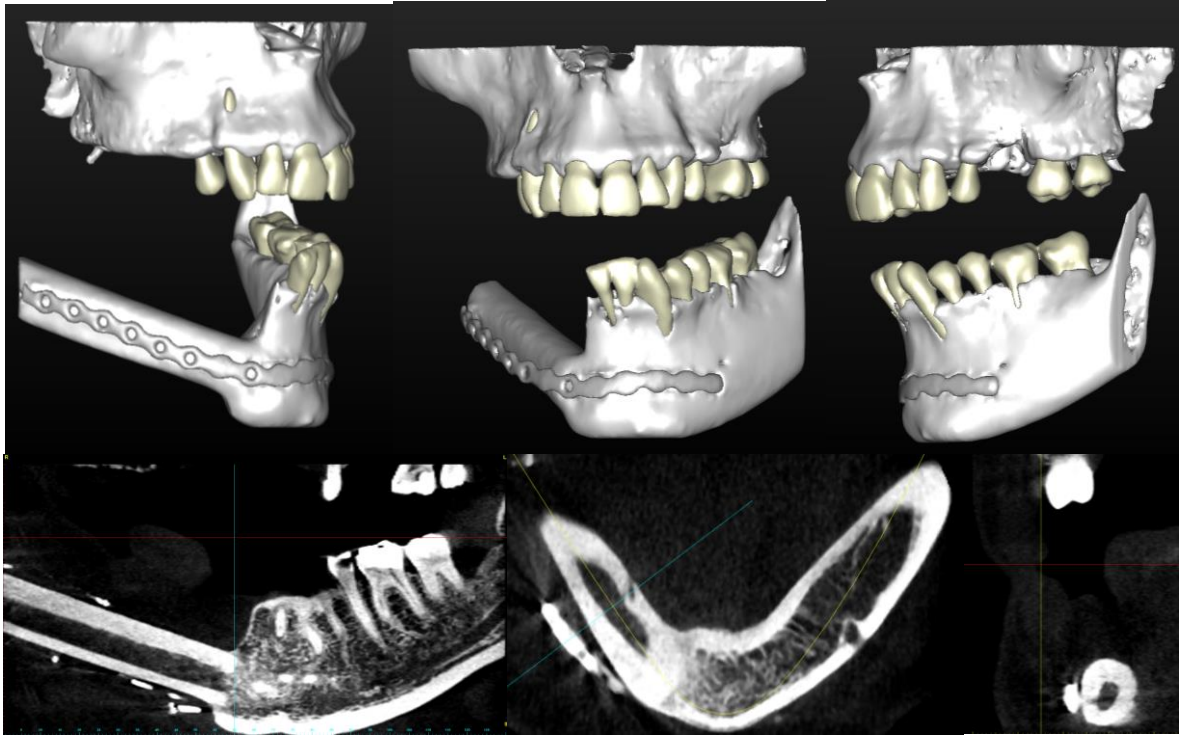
CBCT of H&N oncology patient reconstructed with a single barrel fibula free flap showing the 3D reconstructed image and the CT scan viewed in coronal, transverse and sagittal sections.
